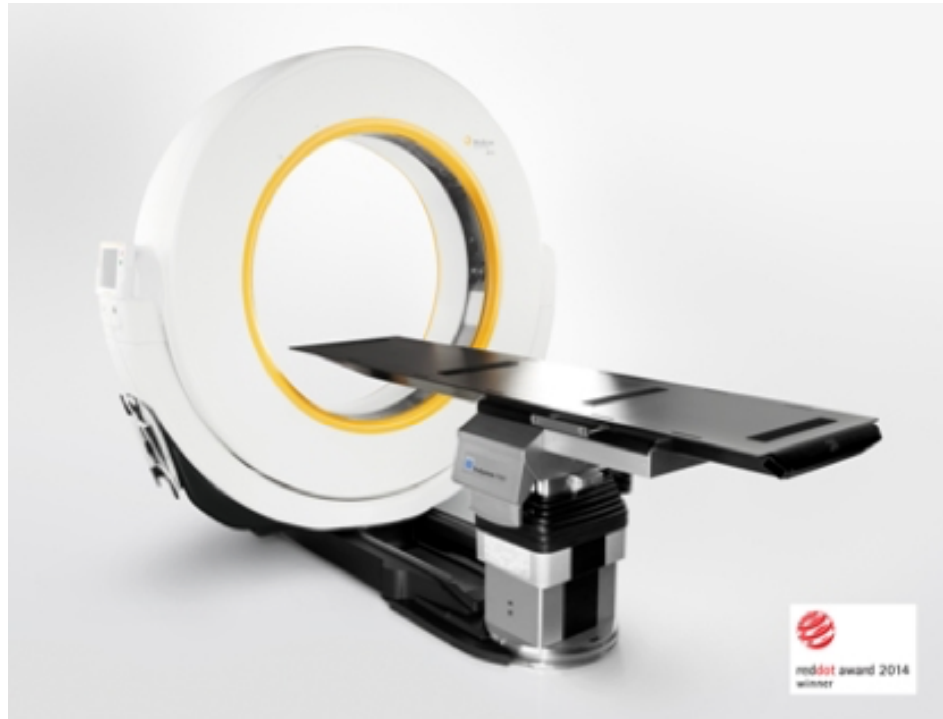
Intra-operative computed tomography (iCT).
